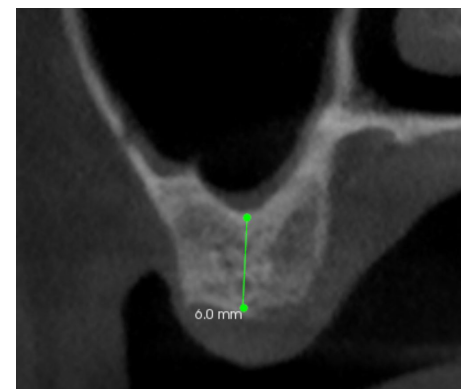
CBCT cross-section UL7 site
